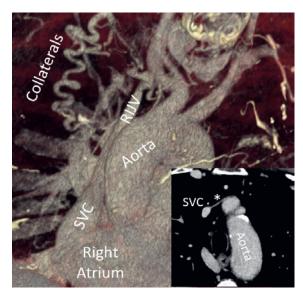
Multiplanar 3D reconstruction of extensive collaterals, right internal jugular vein draining into SVC. Inlay with \* showing axial computed tomography slice of filiform bridging vein. SVC = superior vena cava; RIJV = right internal jugular vein
